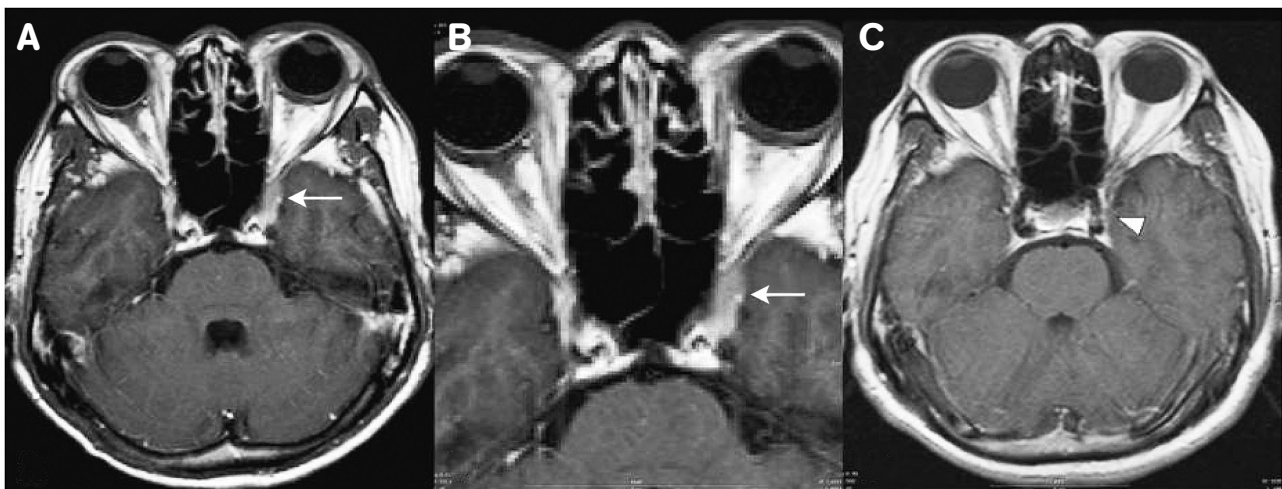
Gadolinium-enhanced T1-weighted axial (A) and coronal (B) images show an enhanced mass involving the left cavernous sinus. Gadolinium-enhanced T1-weighted axial image (C) six months later after steroid therapy shows significant shrinkage of the left cavernous sinus lesion.
